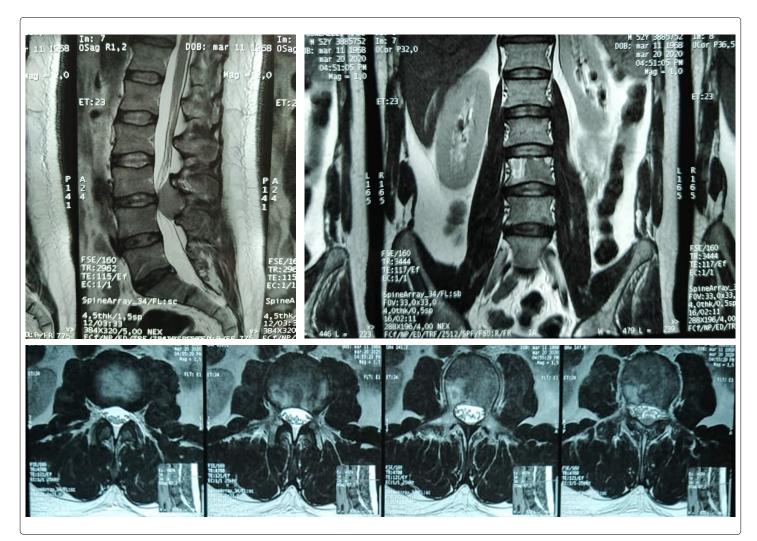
MRI of the lumbar spine. The image observed correspond to central and left foraminal compressive tumor T3 T4 levels.
